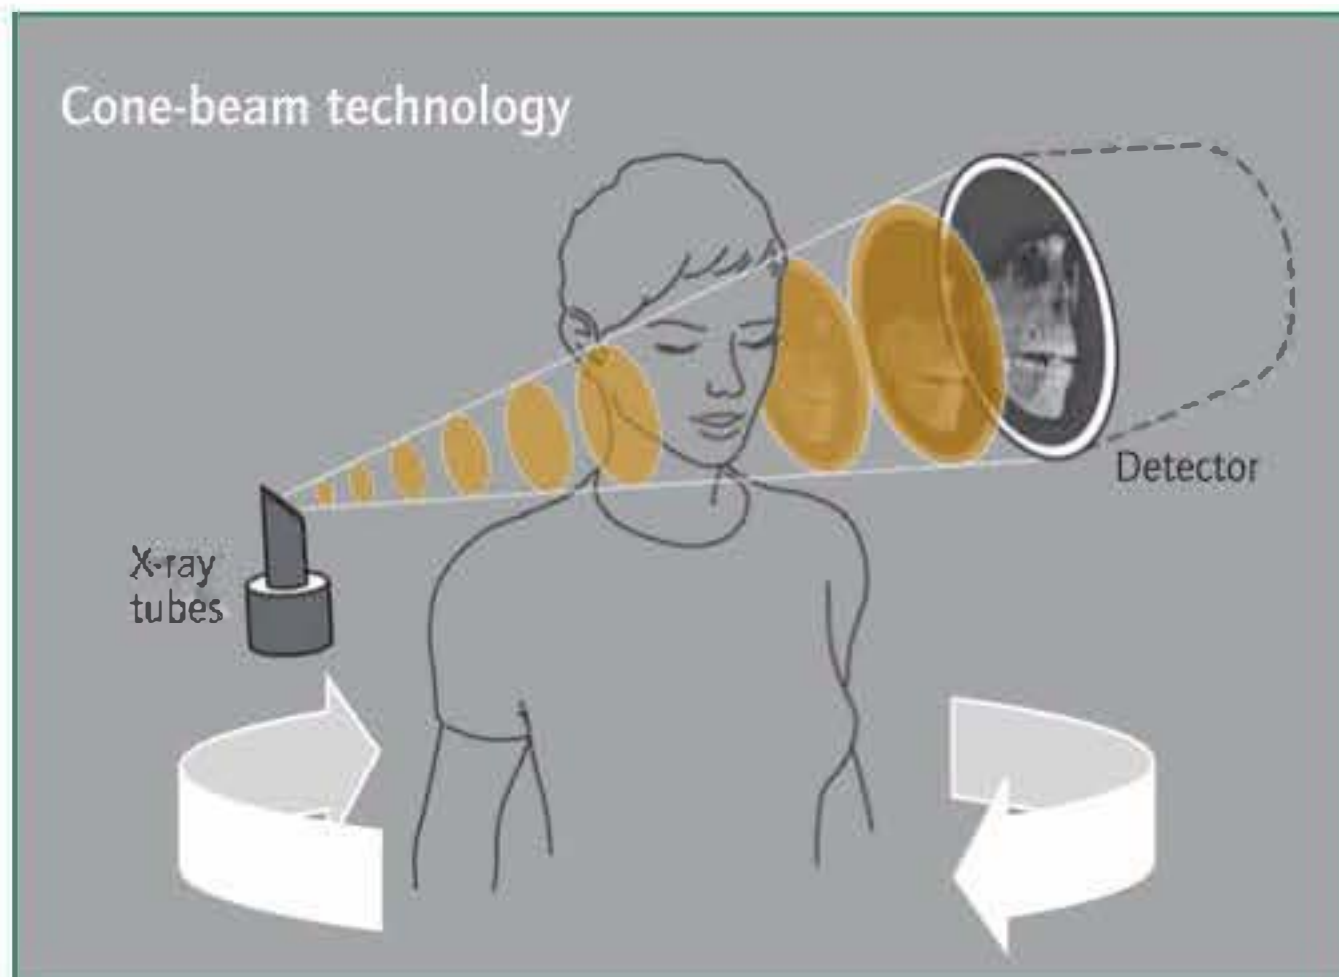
Cone-beam geometry of a dental CBVI system.
